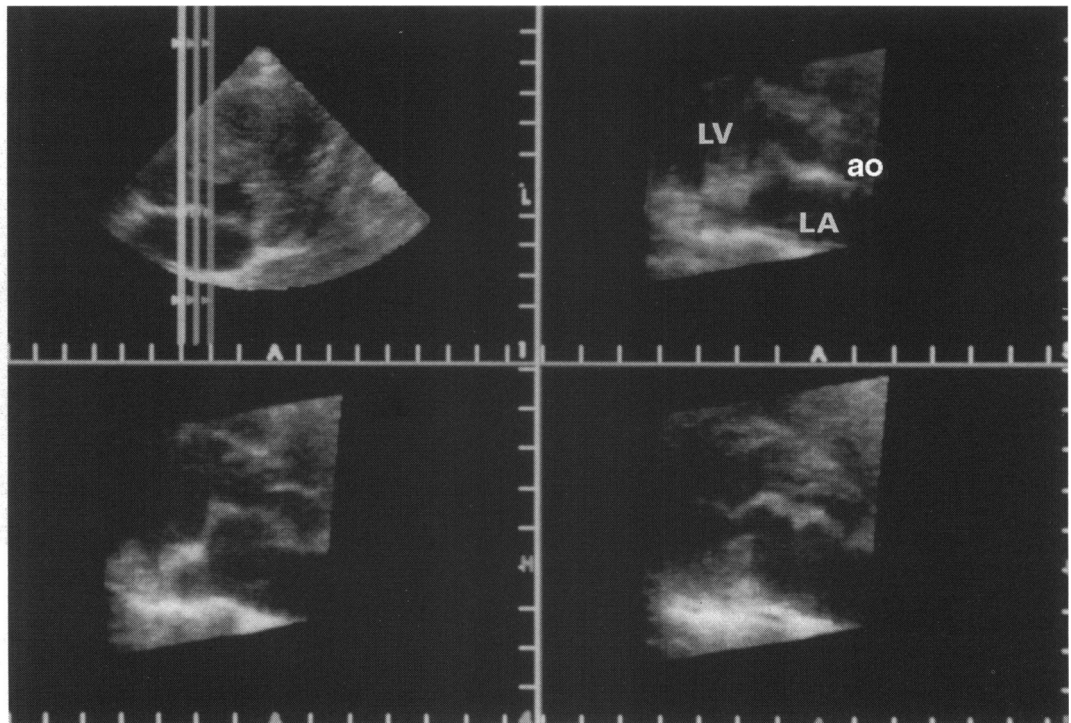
Cross sectional echocardiographic images obtained by slicing in a parallel fashion through the echocardiographically acquired cardiac volume. The upper left hand frame shows the left ventricle and the mitral valve in a view similar to the parasternal short axis view. The three other frames show parallel views 1 mm apart; they are perpendicular to the original view and similar to the long axis parasternal view. LA = left atrium, LV = left ventricle, AO = aorta.
